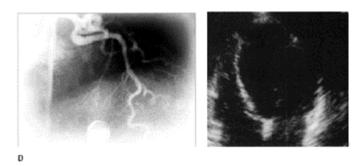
Four weeks after discharge: repeat coronary angiography demonstrates the persistence of left anterior descending coronary artery patency (left), but two-dimensional echocardiography (four-chamber view) shows a dilated, poorly contracting left ventricle (right).
